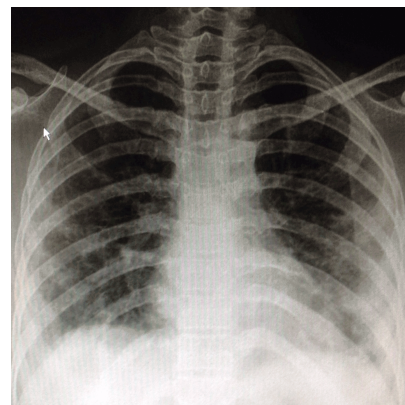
X-ray after one week of steroids showing partial resolution of bilateral illdefined shadows
